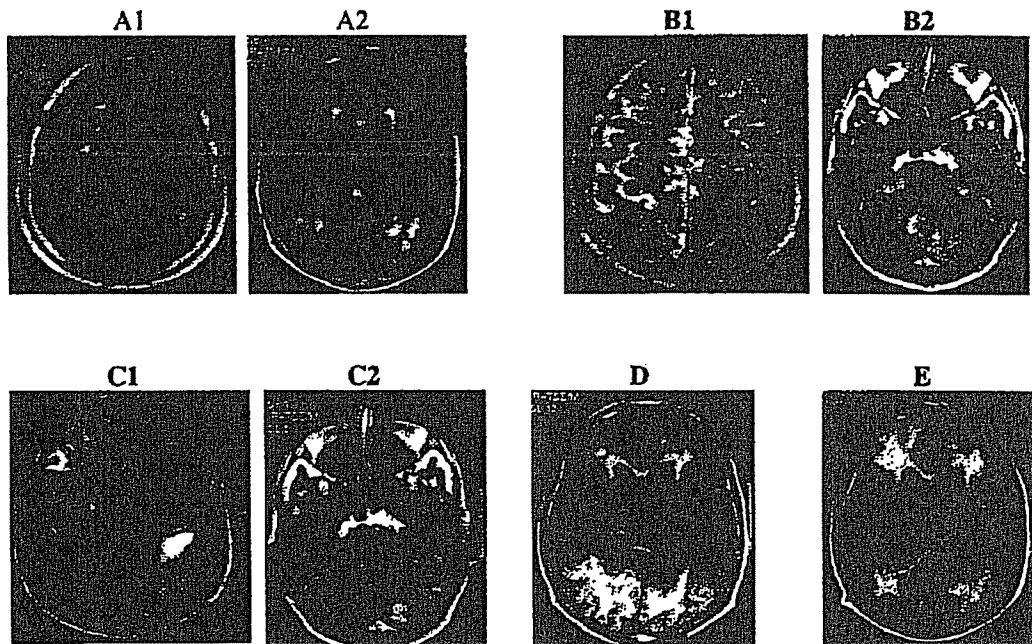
Serial brain MRI scans of Patient 2. A set of fast fluid-attenuated inversion recovery (FLAIR; repetition time = 11,000 milliseconds, echo time = 140 milliseconds, inversion time = 2,500 milliseconds) T2-weighted images performed 22 days (A1 and A2), 41 days (B1 and B2), 64 days (C1 and C2), 87 days (D), and 170 days (E) after immunization. (A) Presence of high signal intensities in the subcortical white matter and in the central sulcus (A1); numerous high signal intensities in the deep white matter (A2). (B) All sulci present an increased signal intensity that is related to the presence of protein in the CSF (B1); new lesions in the white matter of the right cerebellar peduncle (B2). (C) Worsening in the number and location of the lesions, now affecting the white matter and the gray matter of the cerebral (C1) and the cerebellar cortex (C2), while the lesions in the cerebellar peduncle have disappeared. (D) Extensive new lesions in the deep posterior white matter also affecting the adjacent cortex. (E) New lesions in the deep frontal white matter, while some lesions in the posterior white matter disappeared. (Courtesy of Prof. Vincent Dousset, trial neuroradiologist).
